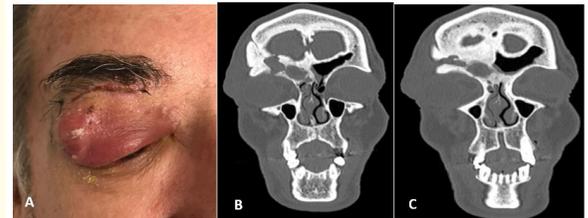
Complicated frontal sinusitis with palpebral abscess. A: Abscess recurred to Draf II and transpalpebral approach with marsupialization of right supraorbital cell to the nasal cavity, B-C: CT showing occupation of the frontal sinus and right supraorbital cell with erosion of the posterior and anteroinferior wall, D-E-F: Removal of bone-like material from the frontal sinus by modified Lothrop approach, G-H-I-J: Transpalpebral approach to supraorbital cell, resection of the mucosa and drilling of the cell with fat obliteration of the same, K: Postoperative CT, L: Patient with resolution of the infection.
